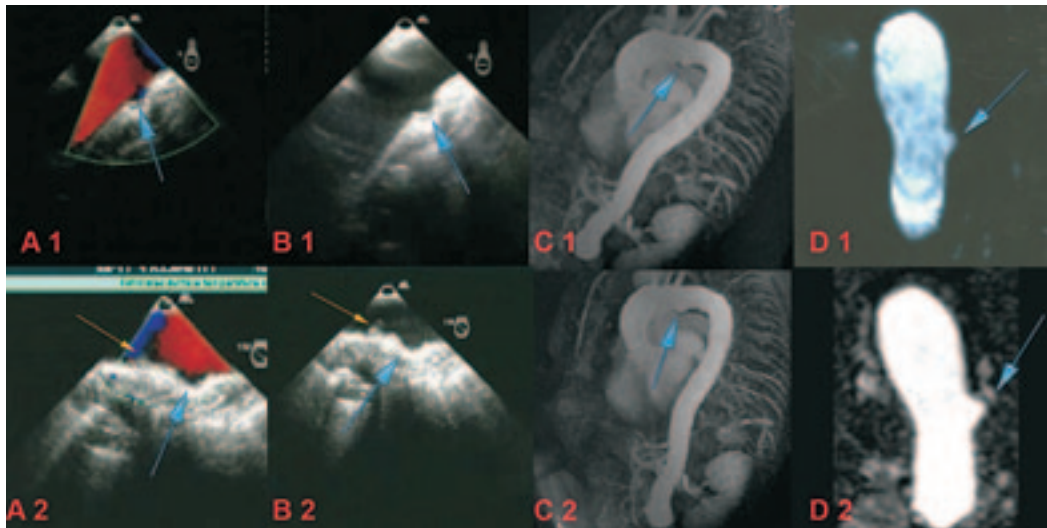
Transoesophageal echocardiography (TEE) with colour Doppler at the aortic arch revealed an atherosclerotic ulcer with retrograde flow within it (small blue-coloured flow at the distal part of the lesion). B1. TEE at the aortic arch revealed an atherosclerotic ulcer. C1. Magnetic resonance angiography of the aorta, modified longitudinal view: an atherosclerotic ulcer in the distal part of the aortic arch. D1. Magnetic resonance angiography of the arch, transverse view: an atherosclerotic ulcer. A2 and B2. Six months later, TEE revealed no significant changes in the dimensions of the atherosclerotic ulcer. Only the growth of an atherosclerotic plaque at the distal edge of the ulcer was identified (yellow arrow). C2 and D2. Six months later, magnetic resonance angiography of the aorta and the arch showed no significant change in the atherosclerotic ulcer.
